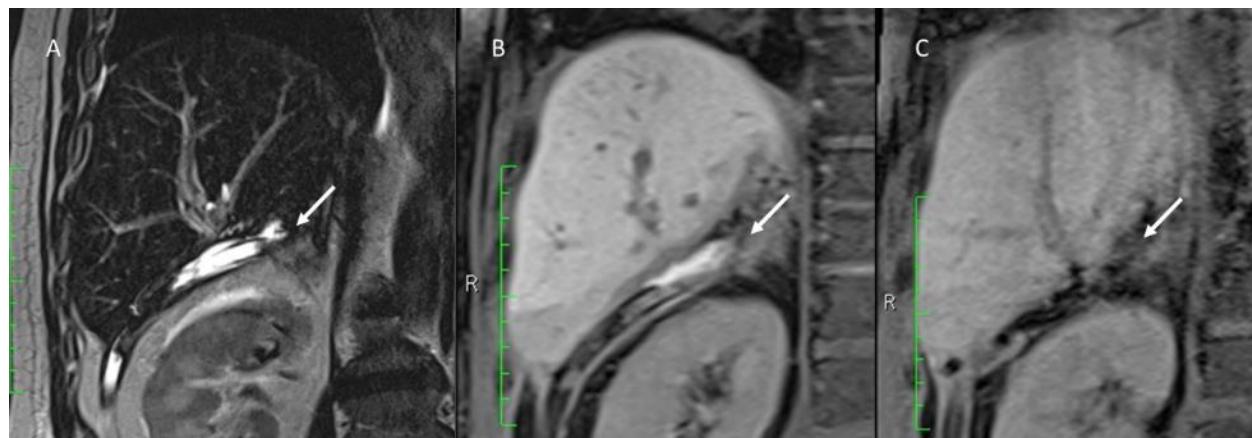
Post-surgical MRI assessment. In (A) T2-W sequences shows (arrow) fluid collection. In (B), On EOB-phase, bile leak is detected as an active overflow of contrast material outside biliary tree and inside the fluid collection (arrow). In (C) EOB-phase post bile leak treatment evaluation, no overflow of contrast medium.
